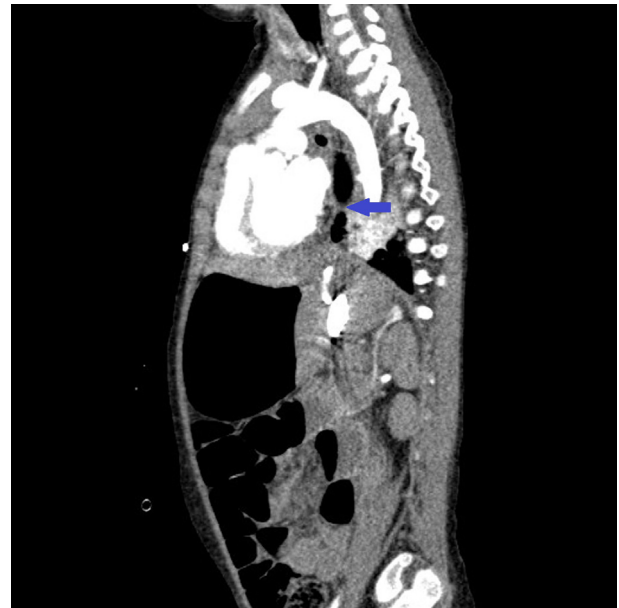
Sagittal reformat based on contrast-enhanced CT of the chest indicating a linear enhanced structure arising from the anterior mid-thoracic aorta where the “arrow-head” represents the aorto-esophageal fistula.
